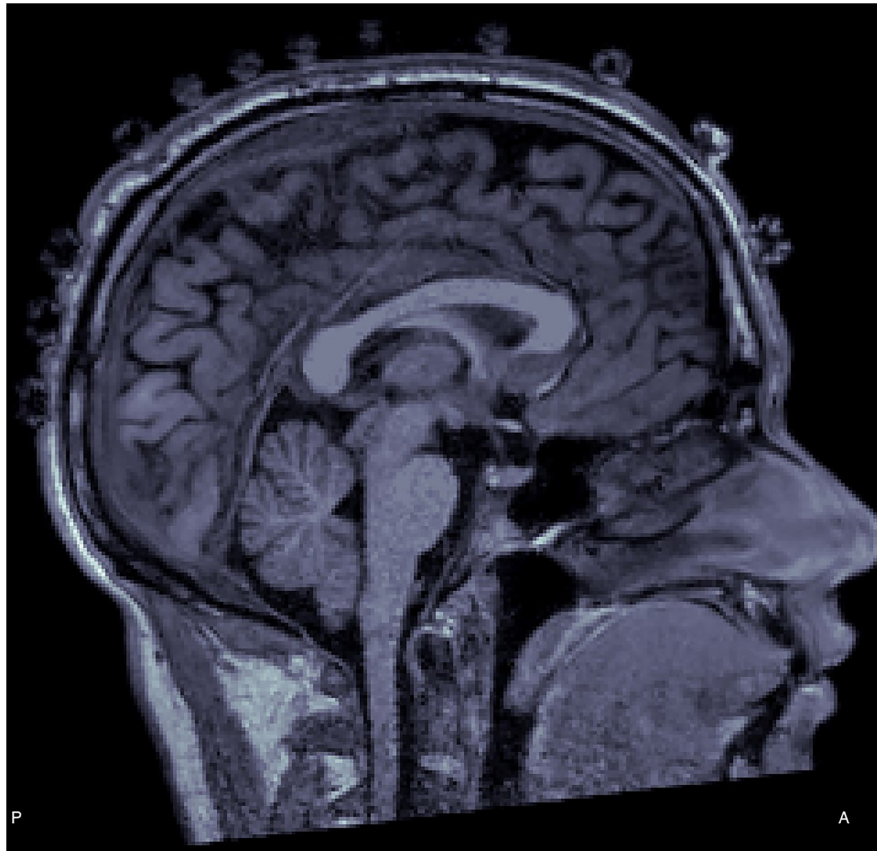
T1-weighted (T1W) structural image with electrode protrusions appearing over the scalp.
